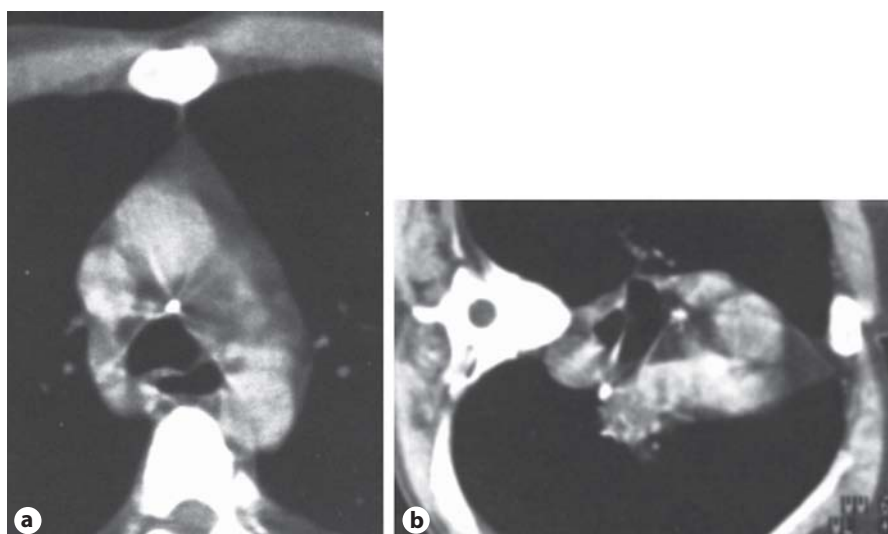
Anatomy of the mediastinum on a computed tomography reconstruction of the coronary section level.
